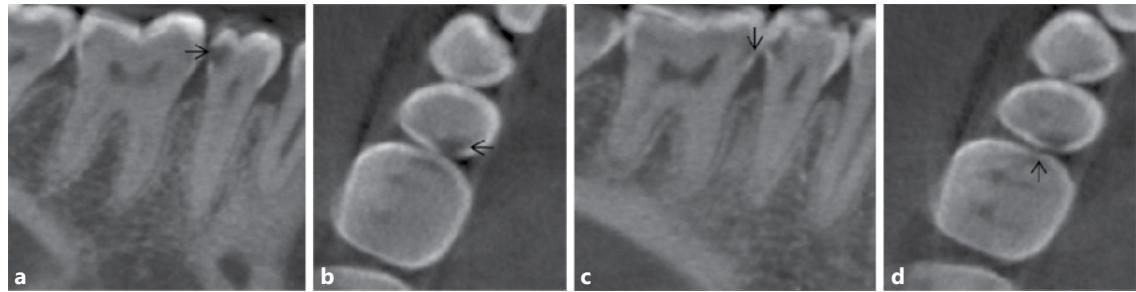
The same proximal lesions as seen in figure 1 displayed in sagittal and axial CBCT sections confirming cavitation on the distal surface of the second premolar (a, b), but scored also as cavitation on the mesial surface of first molar (c, d).
